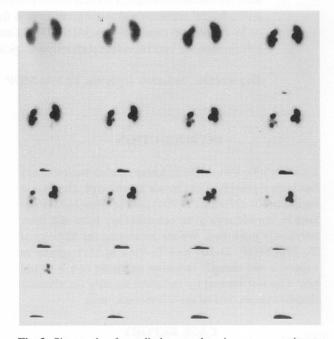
Six months after radiotherapy, there is a more prominent cortical defect corresponding to the area of the left kidney affected from radiation field due to cortical scar at the concentration phase of Tc-99m MAG3 scintigraphy (arrow). The slight activity retention is seen in the adjacent calyces to cortical scar.
